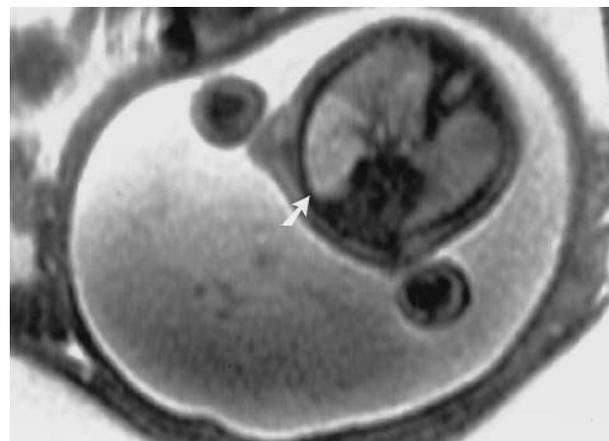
Transverse fetal MRI image shows an abnormal right upper lobe of the lung (arrow) in patient 9.
